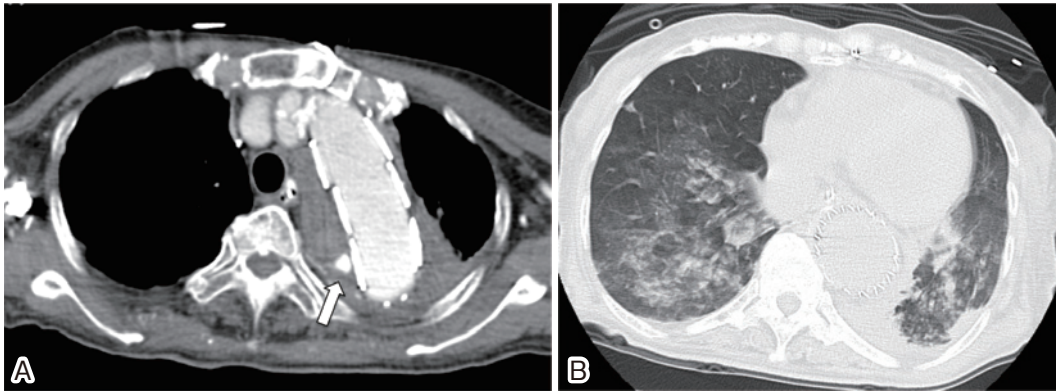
Contrast-enhanced CT shows the expanding aneurysm (62 mm in diameter) and endoleak nidus (arrow) with left pleural effusion on the soft tissue window (A); and bilateral consolidation and ground glass opacity with lower lobe predominance on the lung window (B), which represents intra-alveolar hemorrhage.
